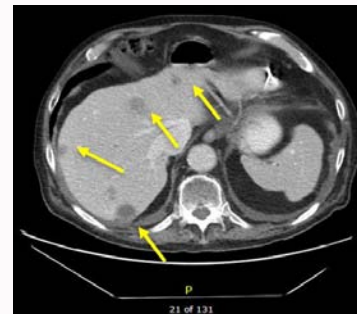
CT abdomen pelvis showing hepatic mets.
